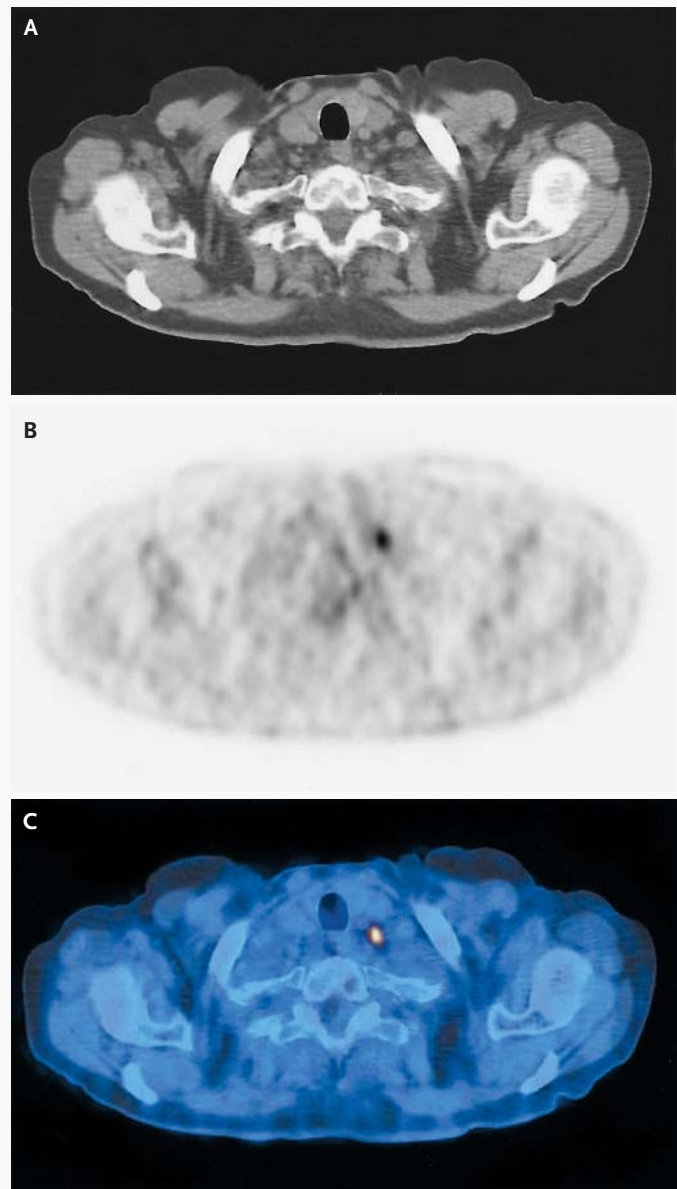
CT Scan, Attenuation-Corrected PET Scan, and Coregistered PET-CT Scan in a Patient with Non-Small-Cell Lung Cancer.
